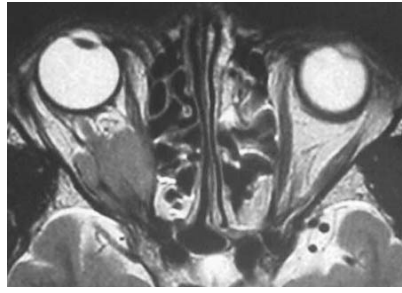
Axial magnetic resonance imaging of case 2 revealed a mass measuring 2.0×2.0 cm in the retrobulbar compartment of the right orbit causing proptosis.
